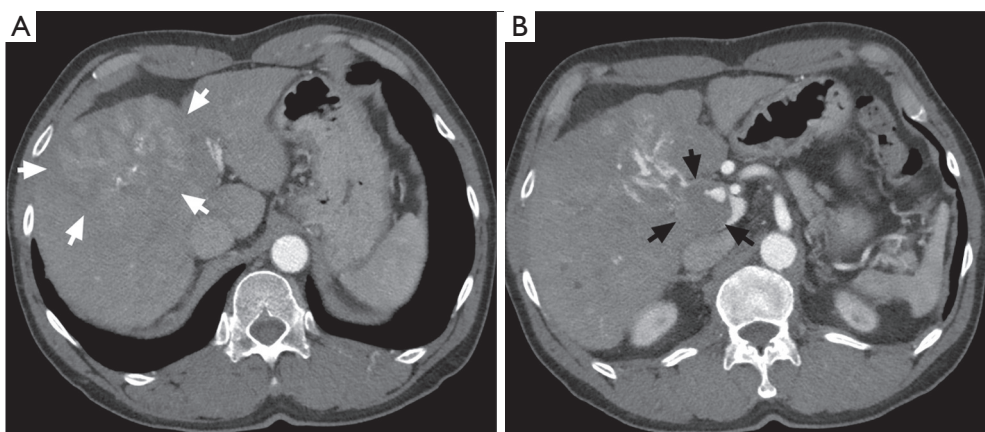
Contrast-enhanced CT image of patient 1. The huge mass in the right lobe with a high-low pattern was consistent with HCC (white arrow). The tumor thrombus in the portal right branch extended to the main trunk (black arrow). CT, computed tomography; HCC, hepatocellular carcinoma.
